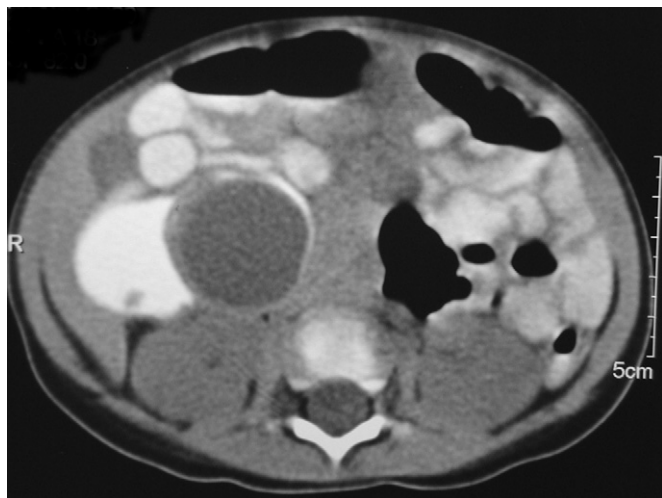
Computed tomography scan from an infant showing a cystic duplication of the ileum with an enhancing rim.
